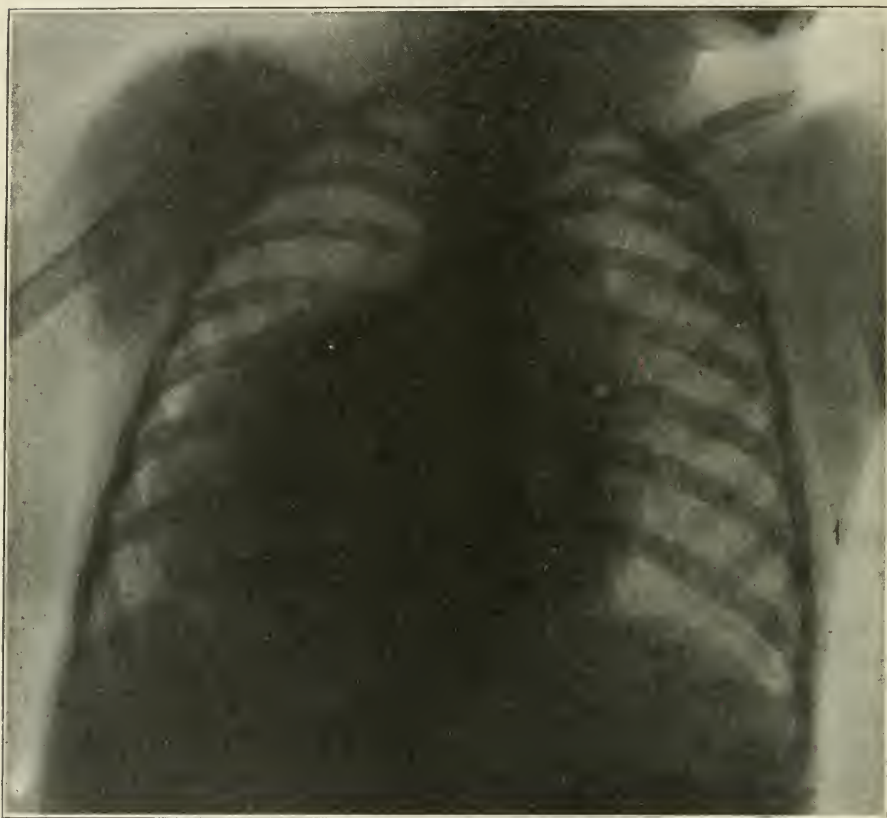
Roentgenogram showing dextrocardia.
